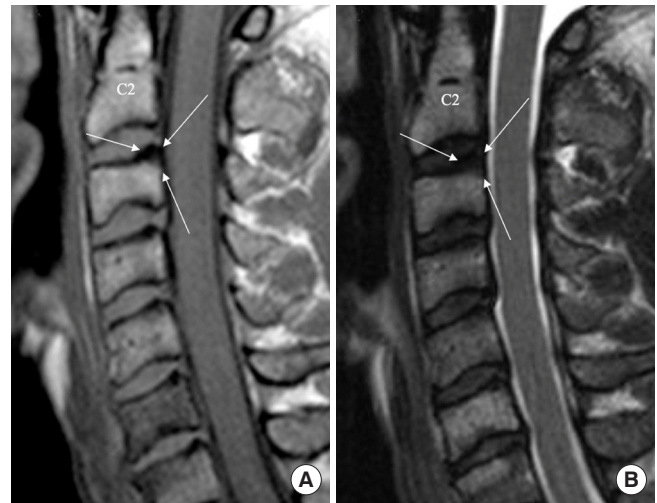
(A) T1-weighted MRI of a 50-year-old female demonstrating hypointensity at the posterior-superior endplate of C3. (B) T2-weighted MRI of the same patient also demonstrating hypointensity at C3, suggesting a type III Modic change. She underwent a 2-level anterior cervical discectomy and fusion procedure of C5–7. Arrows indicate the location of the identified Modic change lesion on T1- (A) and T2-weighted (B) imagings.
